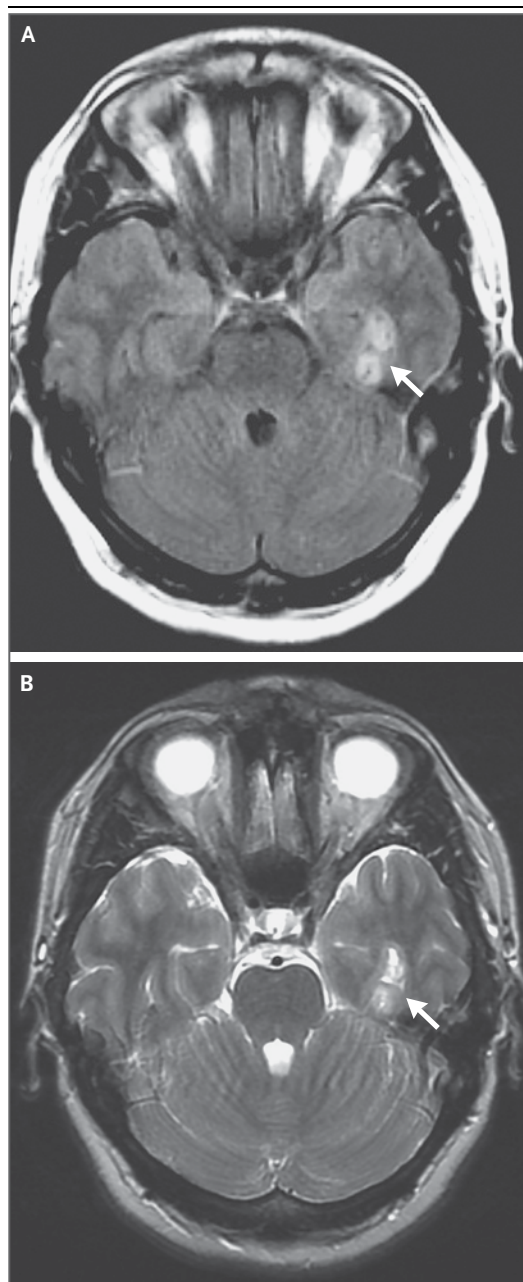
MRI Images of the Brain.
